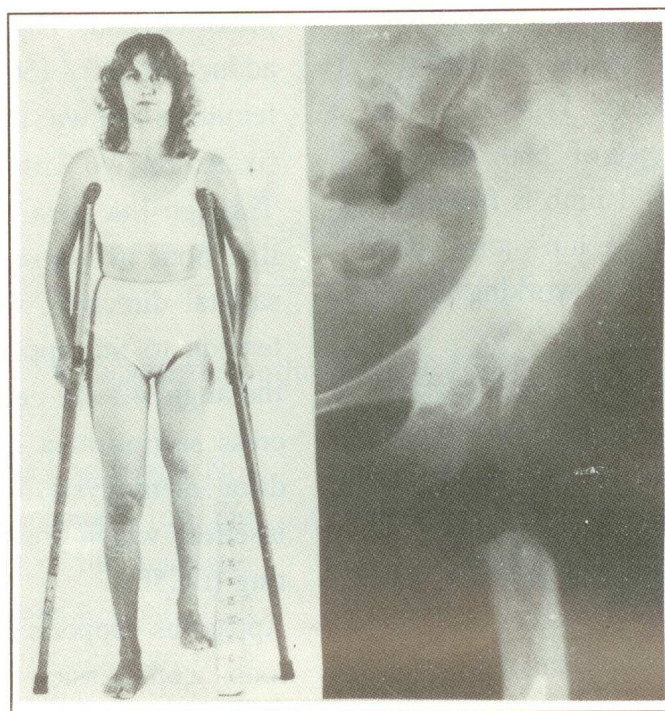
Patient and X-ray on admission
